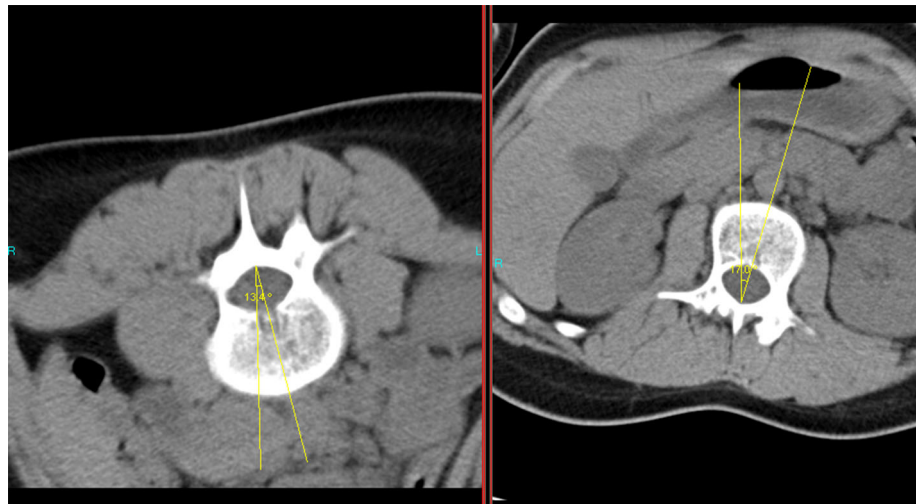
Axial CT images of the thoracic apical vertebra (T11 vertebra) of a 15-year-old girl with Lenke Type 1A AIS. *Left* CT image with  $9^\circ$  in supine position. *Right* CT image with  $9.7^\circ$  in prone position
